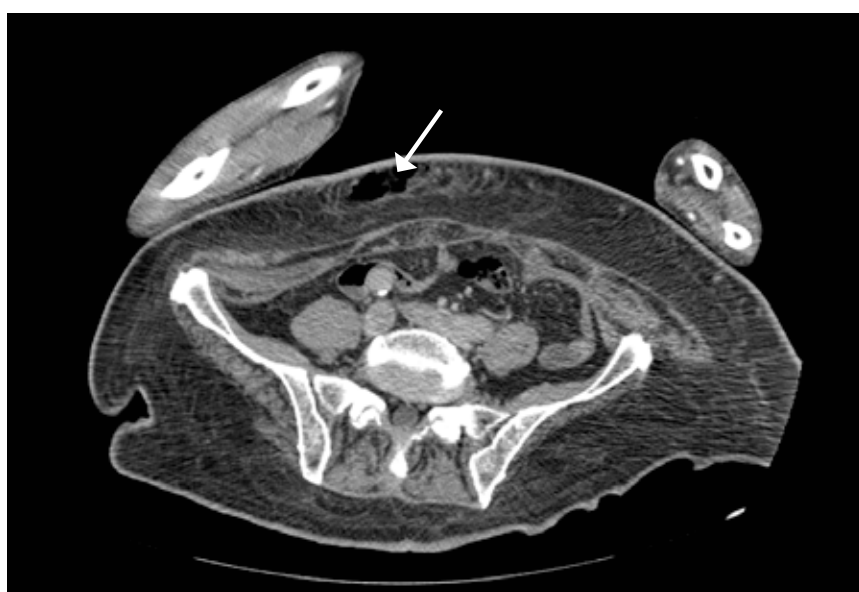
The CT scan of the abdomen showing gases in the abdominal wall (arrow).
